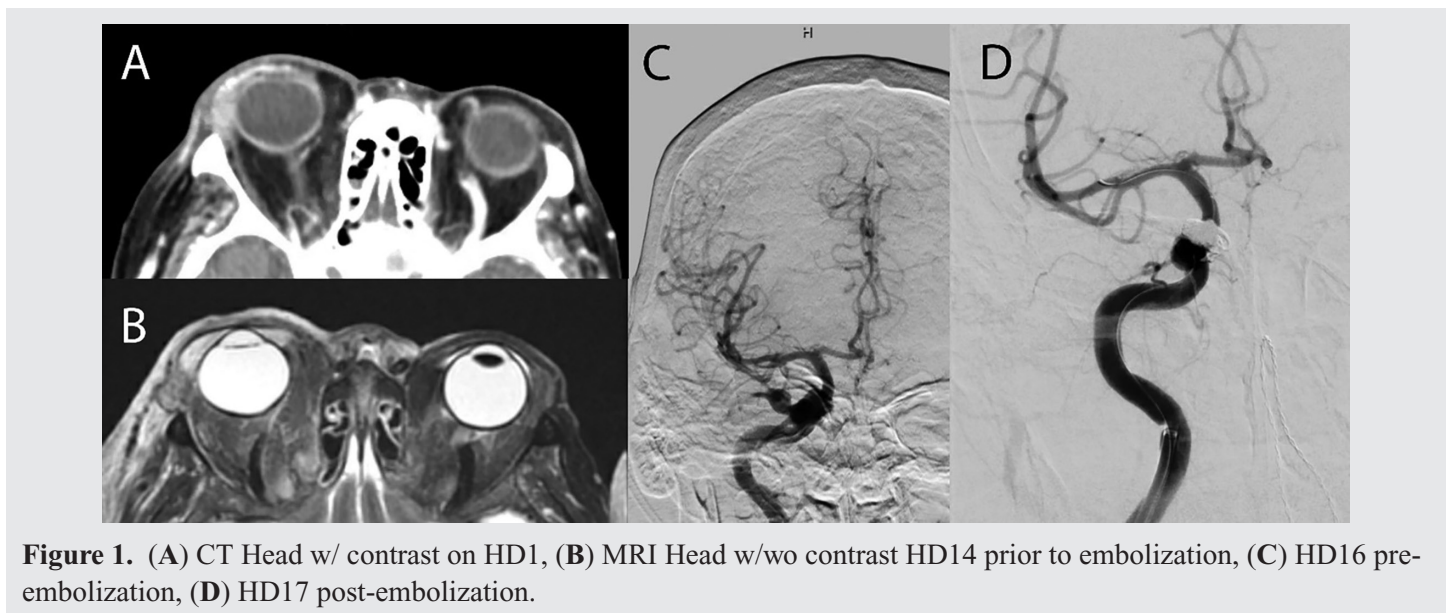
(A) CT Head w/ contrast on HD1, (B) MRI Head w/wo contrast HD14 prior to embolization, (C) HD16 pre-embolization, (D) HD17 post-embolization.
